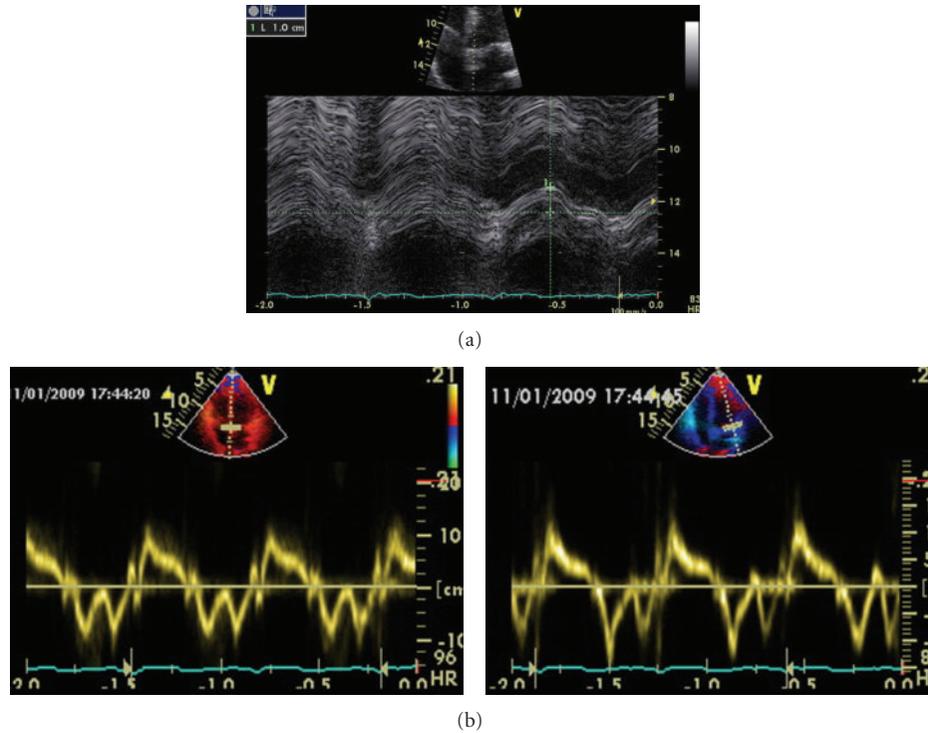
Methods for measuring LV function. (a) Atrioventricular plane displacement (septal wall) using M-mode, showing abnormal (decreased) displacement. (b) Systolic tissue Doppler measurement at the septal and lateral walls using tissue velocity imaging with pulsed wave Doppler, showing normal velocities.
